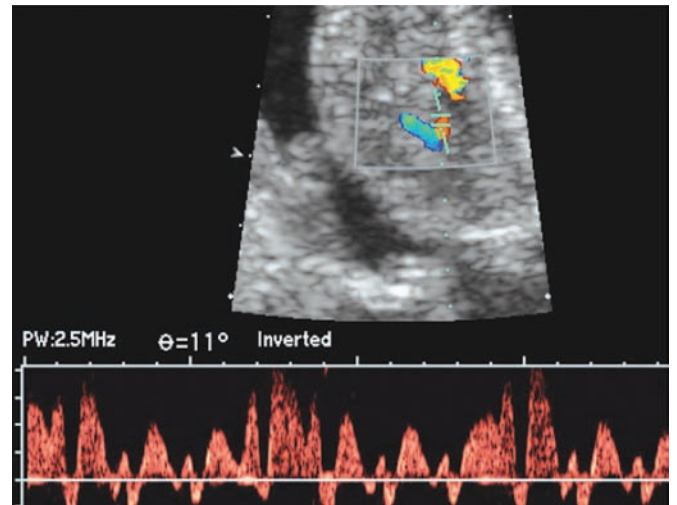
Doppler flow waveforms during breathing movements in the IVC.
